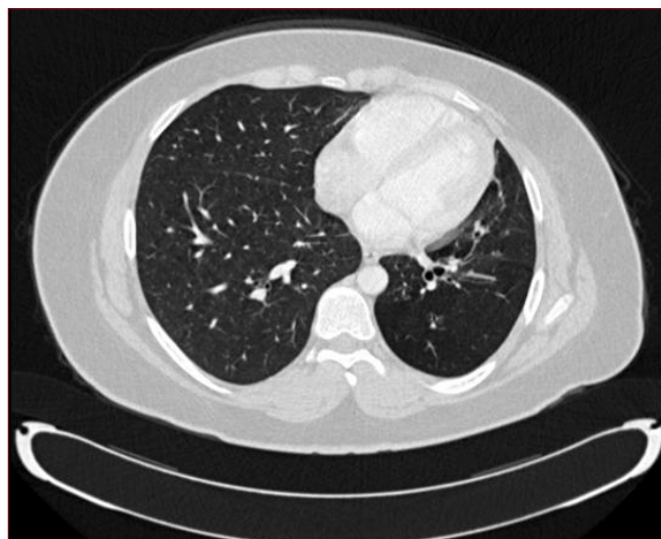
Swyer-James (Macleod Syndrome): radiographic hyperlucent appearance of a left pulmonary lobe.
